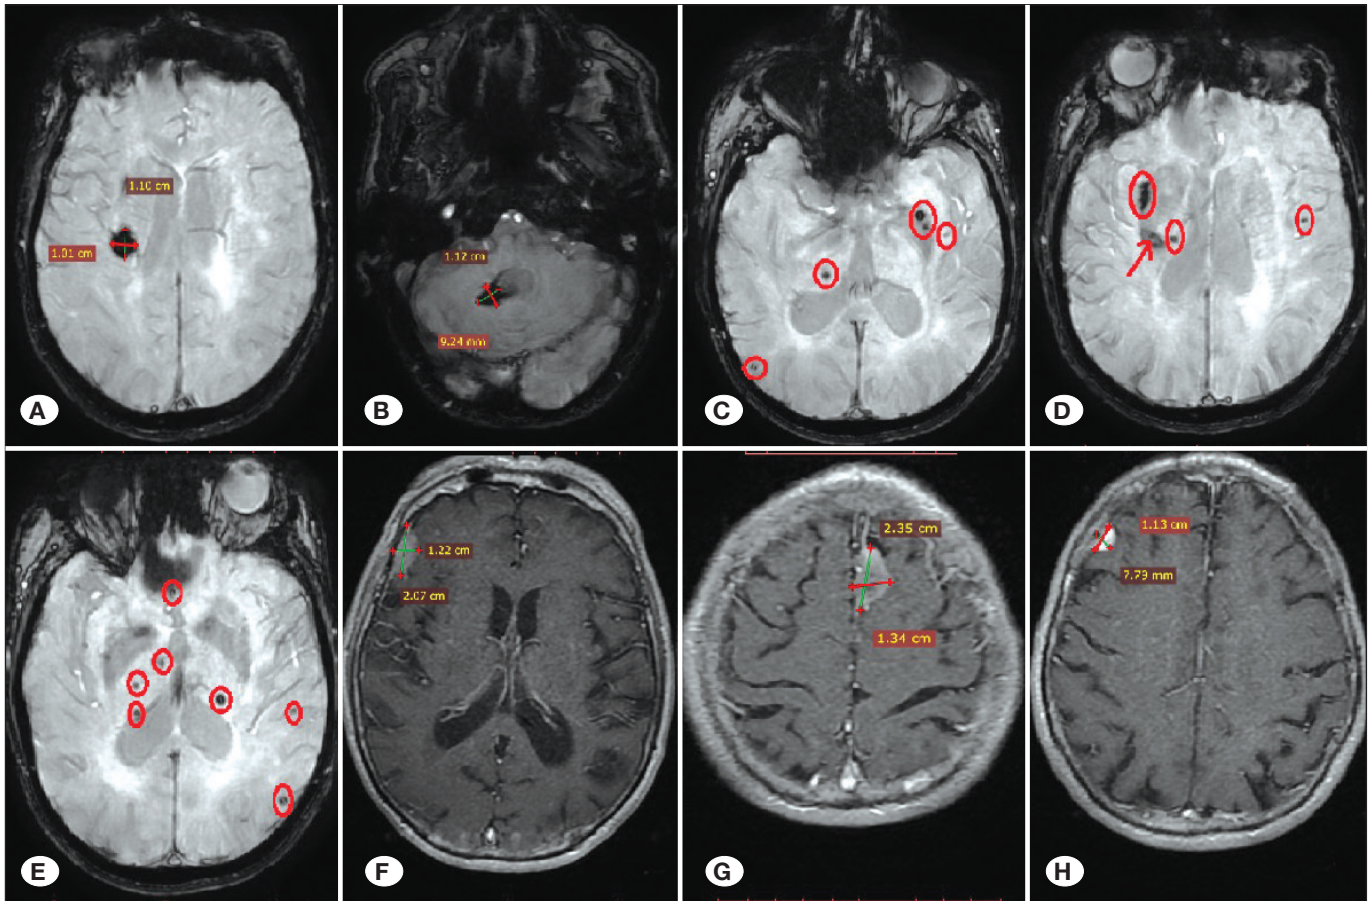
An MRI on 3 months after hemorrhage showing multiple cavernomas and meningiomas. A) Axial SWI-MRI showing a cavernoma in the right basal ganglia measuring 1.10 × 1.02 × 1.5 cm. B) Axial SWI-MRI showing a ruptured cavernoma in the right cerebellum measuring 0.92×1.02×0.9 cm. C–E) Axial sections from an SWI-MRI showing several cavernomas indicated by red circles. Red arrows indicate cavernomas in (D). F–H) Axial T1-weighted MRI showing two right temporal masses (F and H) and a left frontal parasagittal mass (G), all of which show homogeneous contrast enhancement and measure 1.22×1.34×1.8 cm, 2.35×1.34×2.2 cm, and 1.13×0.8×1.2 cm, respectively.
